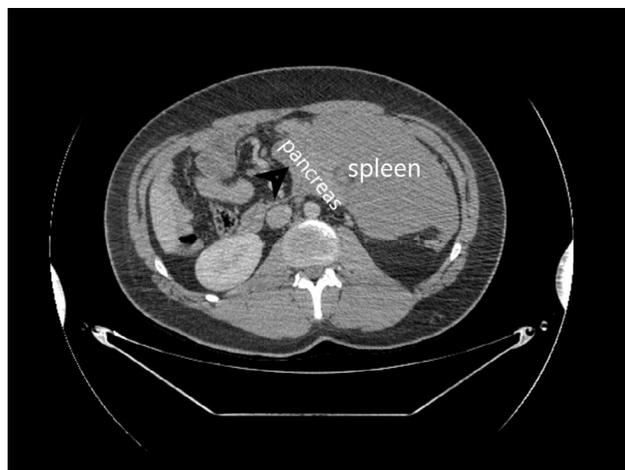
Computed tomography view of the wandering spleen.
